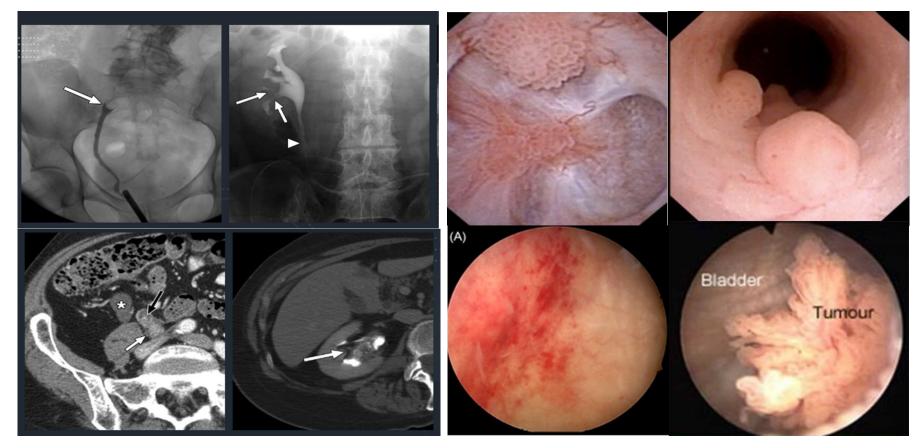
Radiograph and CT depiction of 'filling defects'. Source: https://ajronline.org/doi/full/10.2214/ajr.09.2577 Figure 3: Various urothelial carcinoma presentations. These images provide valuable insights into different manifestations of urothelial carcinoma.
